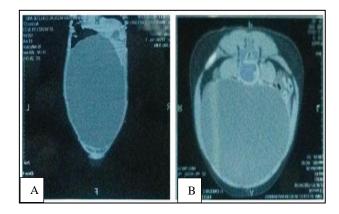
(A and B): CT Image of abdomen and pelvis showing a large ovarian cyst occupying the whole abdomen.
